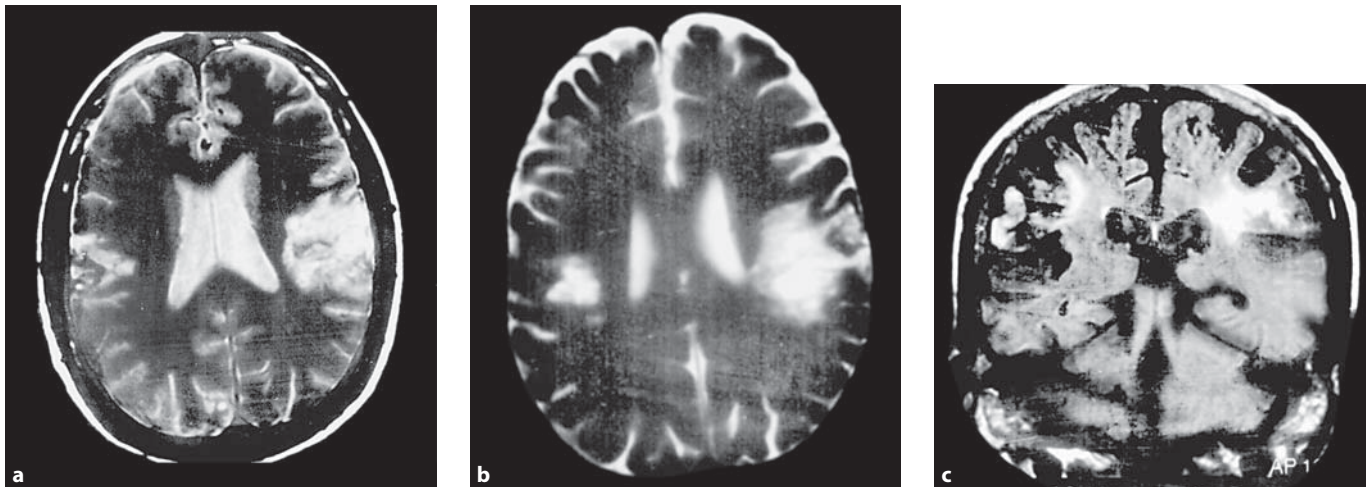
T₂- (a, b) and FLAIR-weighted images (c) in brain MRI showing hyperintense lesions in both parietal opercula (taken from Puertas et al. [18], with permission of Viguera Editores, *Revista de Neurología*).
